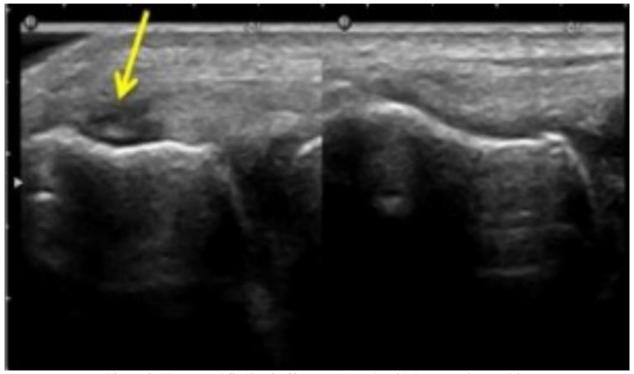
Ultrasound finding in 43 years old male with lateral epicondylitis.
